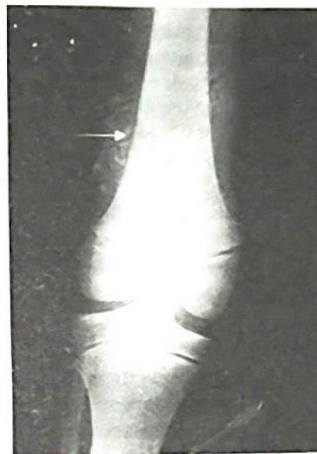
Postero-Anterior plain X-ray of the left knee region on initial admission showing small cortical injury to the distal femur (arrow) and few bony splinters in the soft tissues on the outer aspect of the thigh
